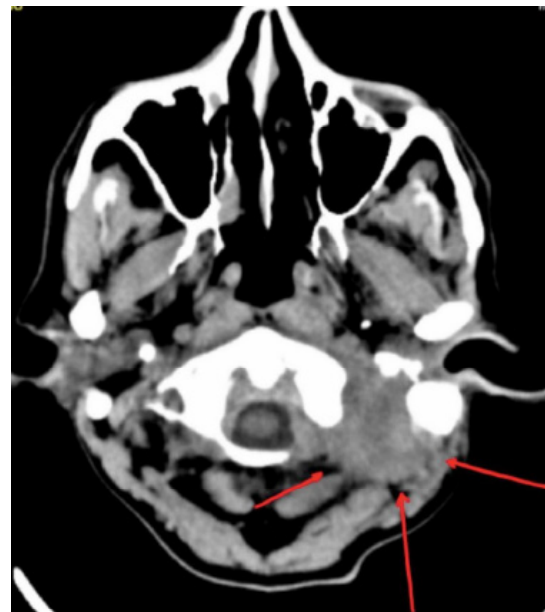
Axial computed tomography angiogram of the head and neck demonstrating a 3.0 x 3.7 x 3.1 cm ill-defined soft tissue density (arrows) centered inferior to the medial aspect of the mastoid temporal bone and lateral to the left occipital condyle with disruption of the fat planes and a central hypodensity concerning for Bezold abscess.
